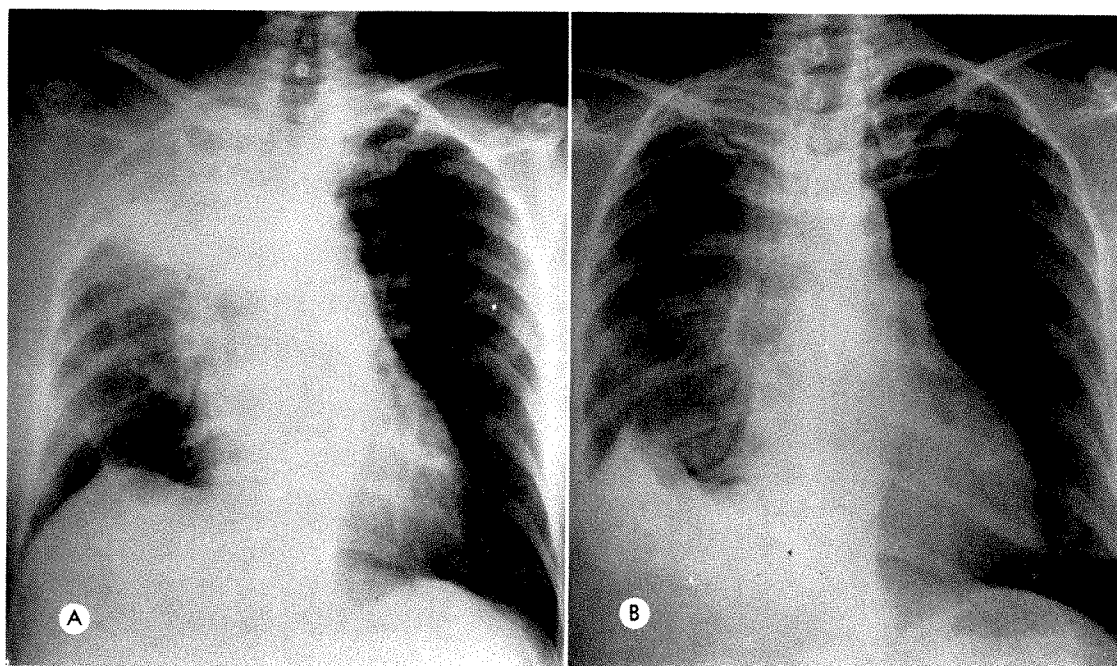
Case III, N.B. May 25, 1959. (A) Supine and (B) erect roentgenograms of the chest of a 56 year old patient $5\frac{1}{2}$ months following rapid radiotherapy for Stage I carcinoma of the right breast (inoperable because of severe rheumatic heart disease). The patient had an excisional biopsy of a 2 cm. mass which demonstrated adenocarcinoma with tumor remaining in the margins of the biopsy. In December, 1958, the patient was treated with 2,500 r tumor dose to the breast and lymph node areas (2 days to each area). A mild erythema at completion of therapy had progressed to moist epidermitis at 1 month and had cleared 2 months following radiotherapy. On May 25, 1959, the patient reported cough and mild shortness of breath, and chest roentgenograms demonstrated fibrosis and pneumonitis of the right upper lobe with right pleural effusion. By 9 months after radiotherapy, symptoms were alleviated although pulmonary fibrosis was still present on the roentgenograms.
